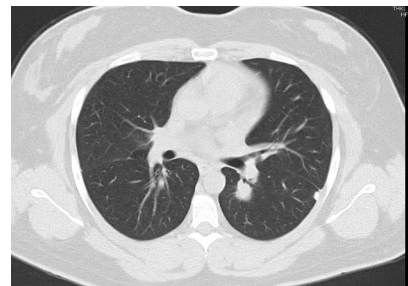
CT chest without contrast with improvement of bilateral basal lung nodules however persistent lingula consolidation.
